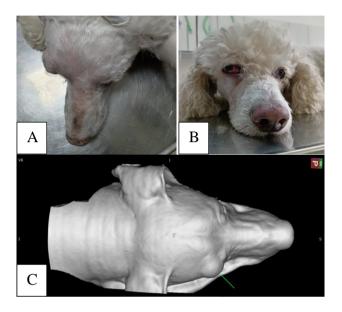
Showing A: The evident proptosis of the right eye; B: Protrusion of the third eyelid and slight divergent strabismus; and C: 3D CT scan with skin between preset. The green arrow indicates the proptosis in the right eye.
